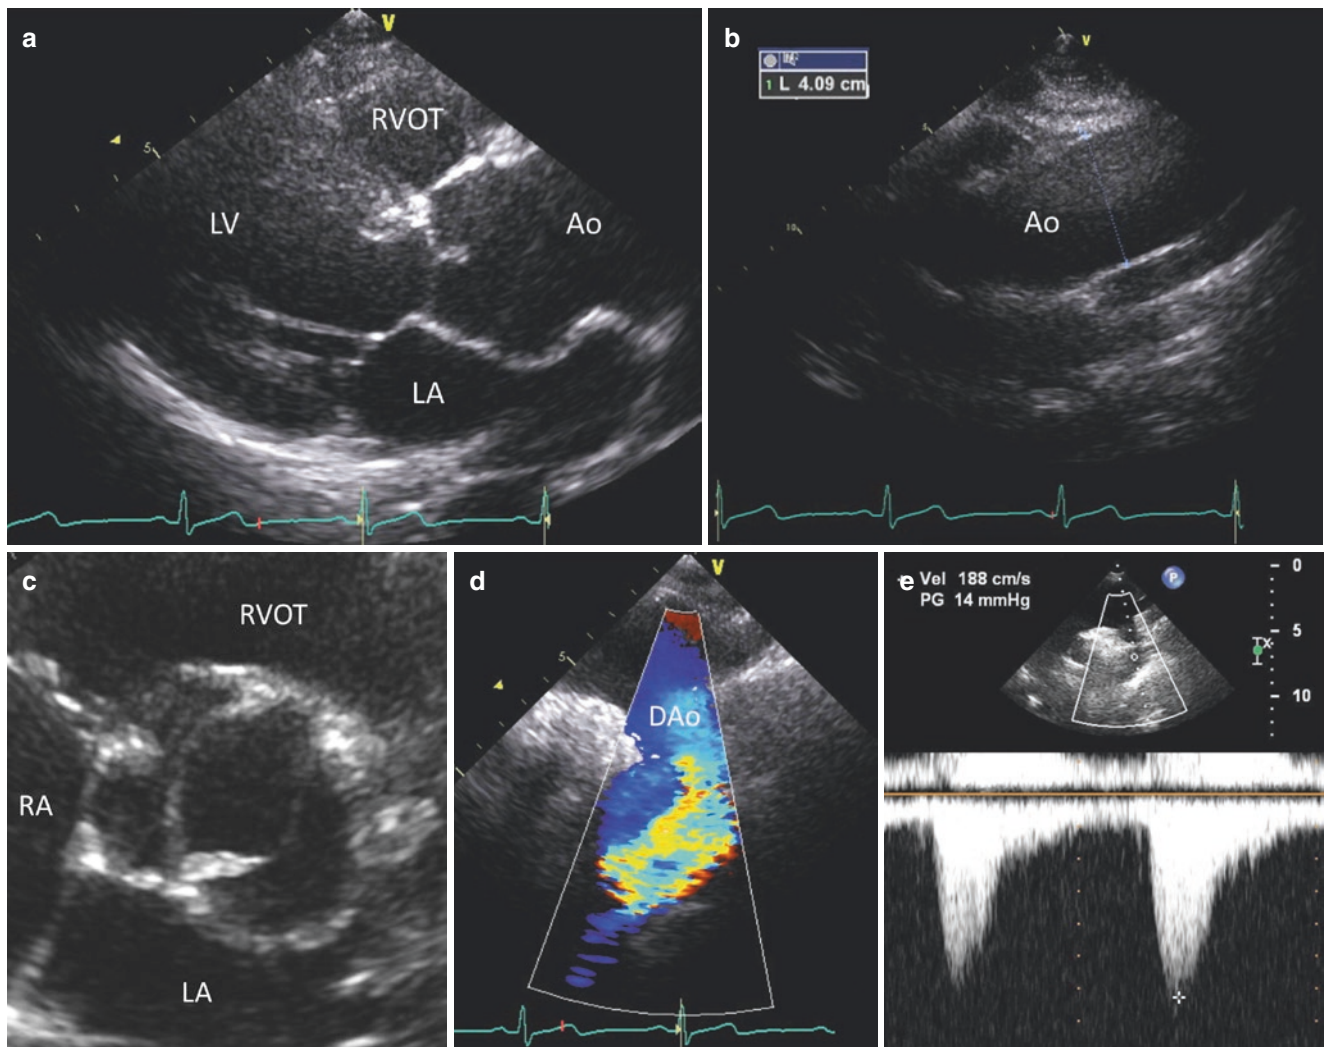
Coarctation of the aorta. (a) and (b) Parasternal long-axis views demonstrate dilatation of the sinuses of Valsalva (panel A) and mid ascending aorta (panel B). For better visualization of the mid ascending aorta, the transducer is moved superiorly and toward the right axilla in panel B. (c) Parasternal short-axis view showing a bicuspid aortic valve, with fusion of the right and noncoronary cusps. (d) Color-flow Doppler assessment of the descending aorta from the suprasternal
